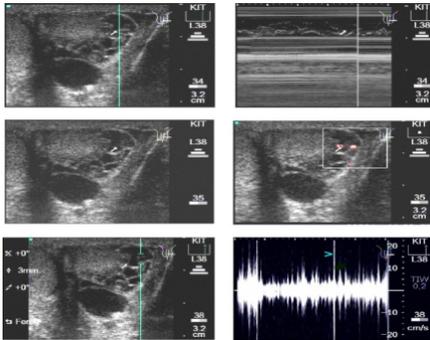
Filariasis, M mode, Power Doppler, Pulse wave showing movement of Filarial worm (Filarial Dance sign)
